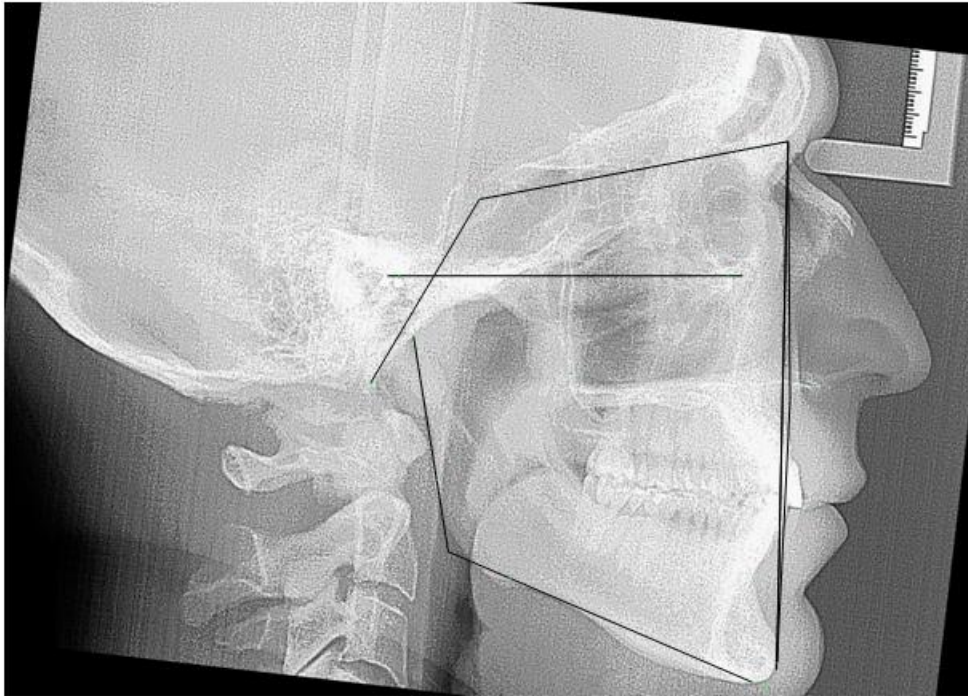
Dolphin Imaging 11.0 traced lateral cephalometric radiograph
